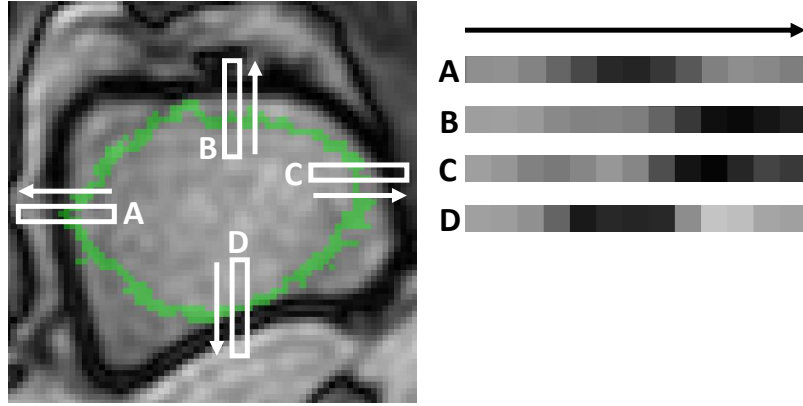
Example of intensity profiles sampled in an MR image of the femur.
